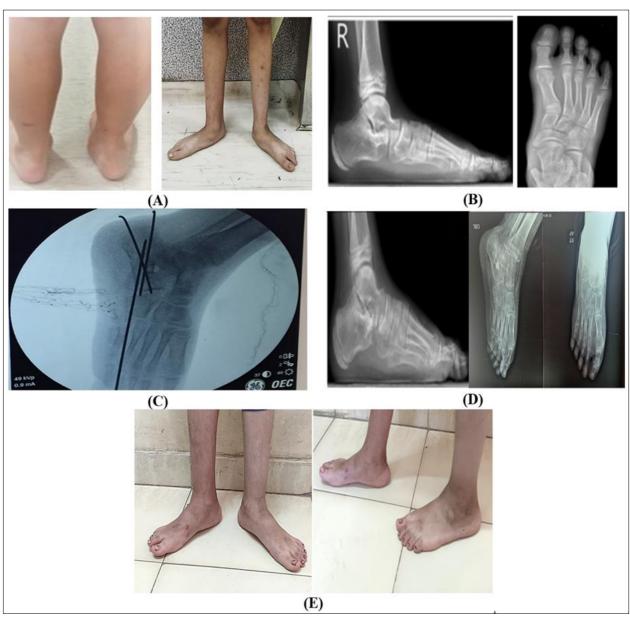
(A) Preoperative photograph, (B) Preoperative radiographs: Standing AP, Lat view, (C) Intraoperative Right foot X -Ray, (D) Right foot X -Ray final follow up, (E) RT foot final follow up photographic
